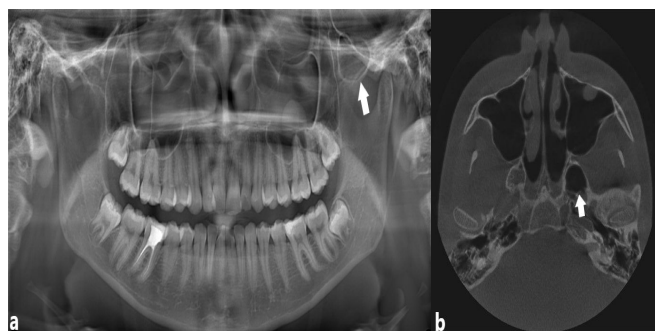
Sphenoid sinus pneumatization (SSP) on the left zygomatic arch in the panoramic image (a) and axial cone-beam computed tomography image (b).
